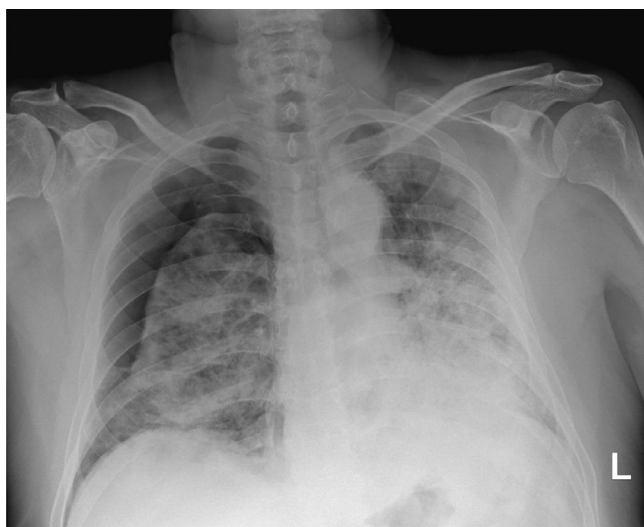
(Patient 3): Admission chest x-ray demonstrating extensive bilateral patchy infiltrates and right-sided pneumothorax.
